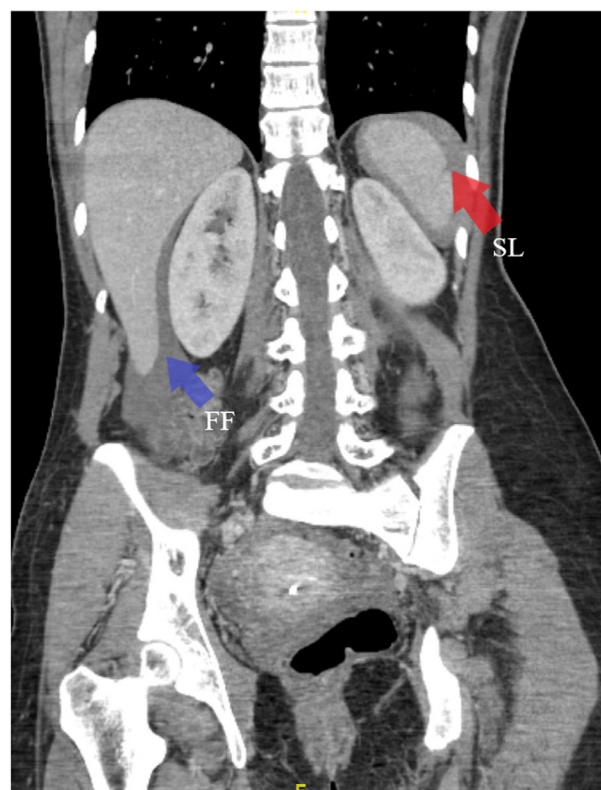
CT scan of the abdomen and pelvis with contrast (coronal view) showing hemoperitoneum (FF, blue arrow) and splenic laceration (SL, red arrow)
